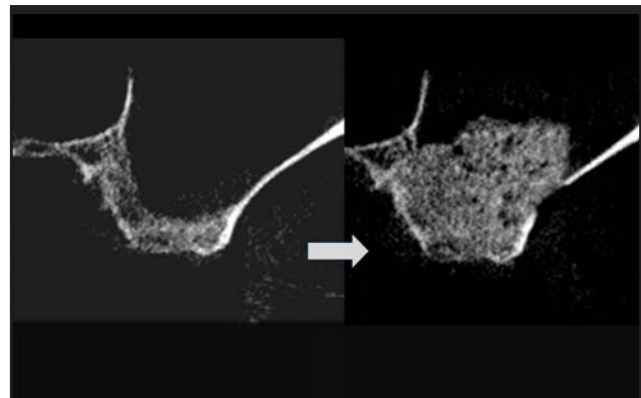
Paraxial CT scans of sinus taken pre and post surgery.
